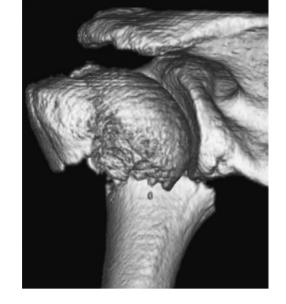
CT with three-dimensional reconstruction Advanced imaging provides a much clearer picture of the injury, allowing better pre-operative planning.
